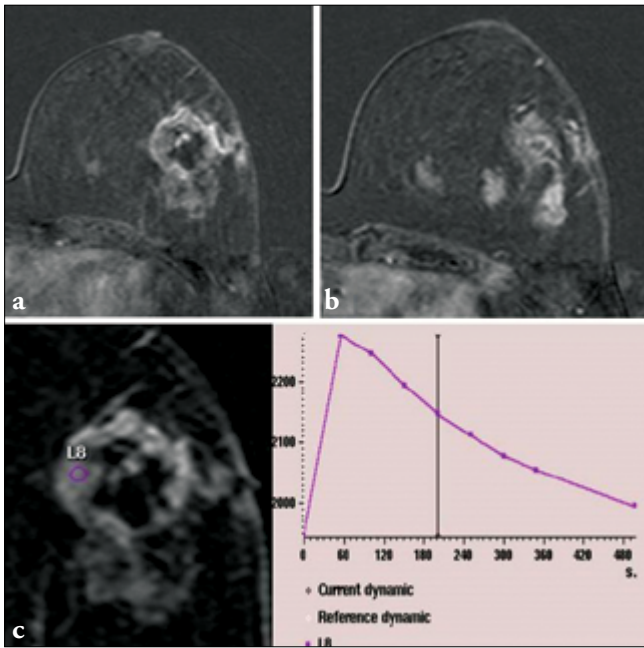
a-c. Dynamic contrast-enhanced MRI and pharmacokinetic curve of Case 1 before treatment. The subtraction image revealed a 6.5 cm, lobulated, irregularly contoured, necrotic mass lesion with skin invasion in the left breast outer quadrant (a, b). Various foci with similar morphologic and kinetic features, the largest reaching 2 cm in diameter, are detected (b). Pharmacokinetic evaluation is compatible with type 3 curve (c).
